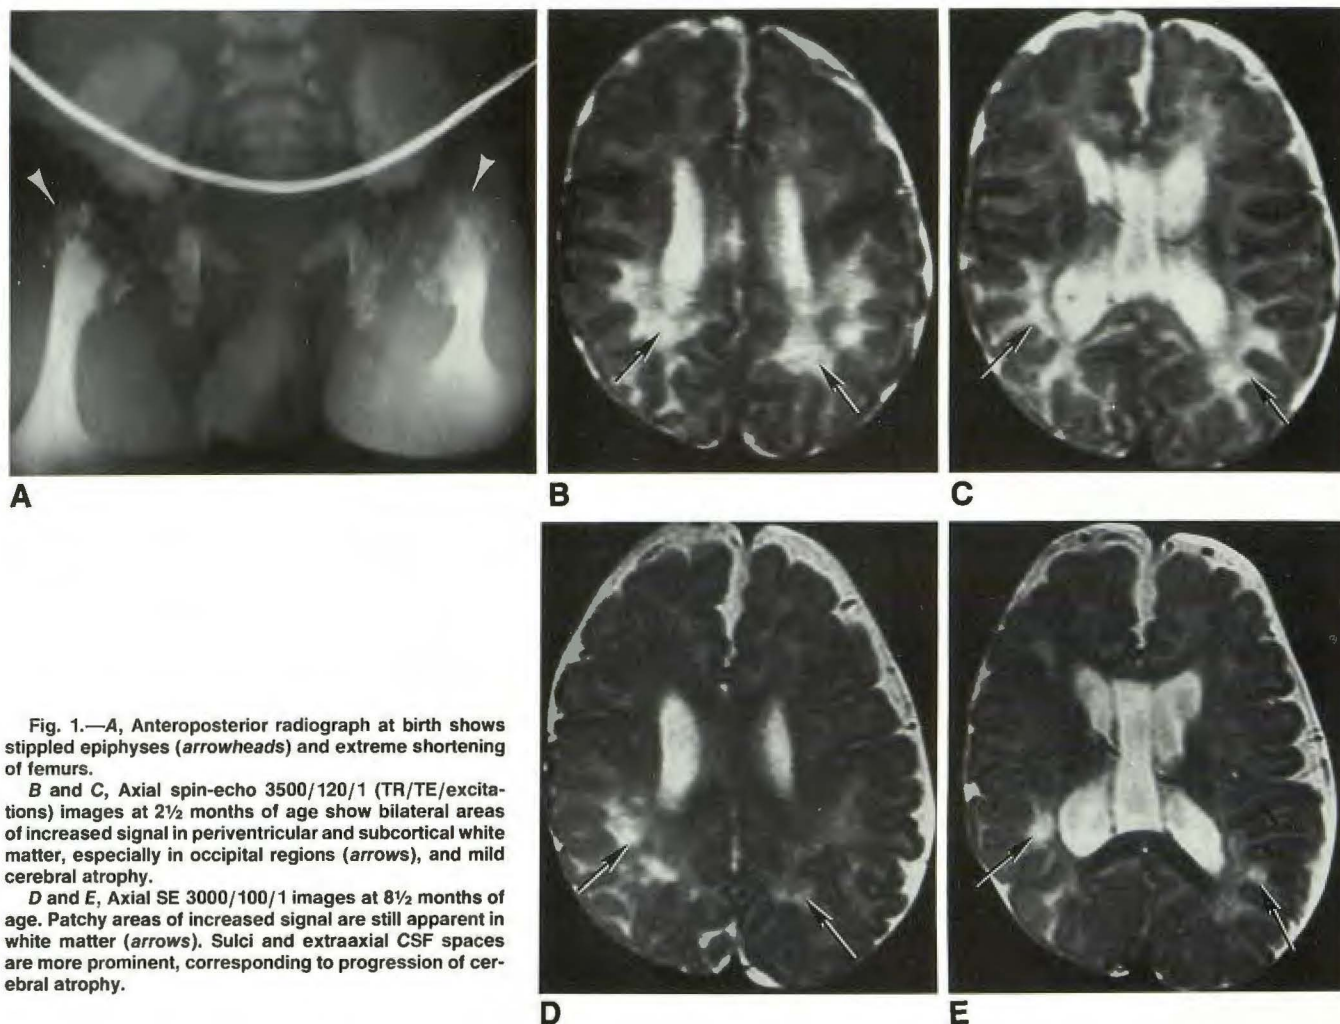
A, Anteroposterior radiograph at birth shows stippled epiphyses (arrowheads) and extreme shortening of femurs.
